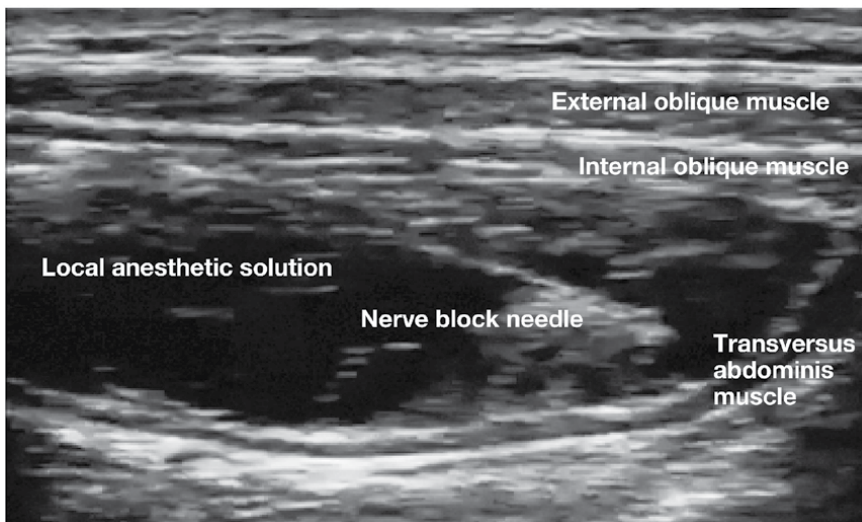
Ultrasound image obtained during transversus abdominis plane block [8]. A local anesthetic solution was injected into the interfascial compartment between the internal oblique and transversus abdominis muscles.*
